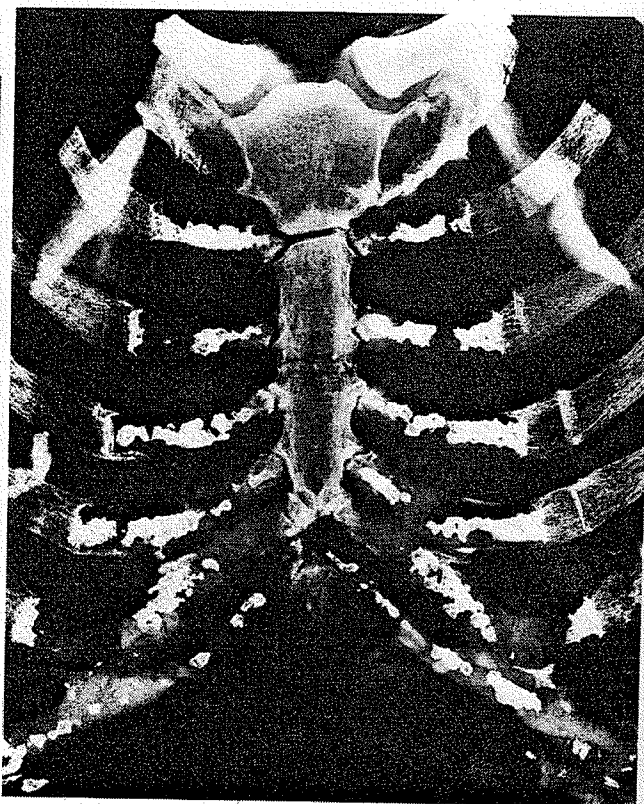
(Figure 2 in text): Photographic Template for Feature Assessment of Chest Plate X-Rays.
